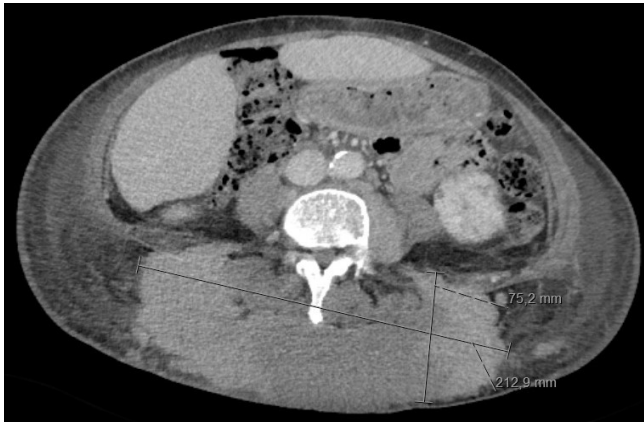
Computed tomography scan showing a large subcutaneous mass of 17x21x7, 5cm, involving the skin and the adjacent left lumbar and gluteal muscles.
